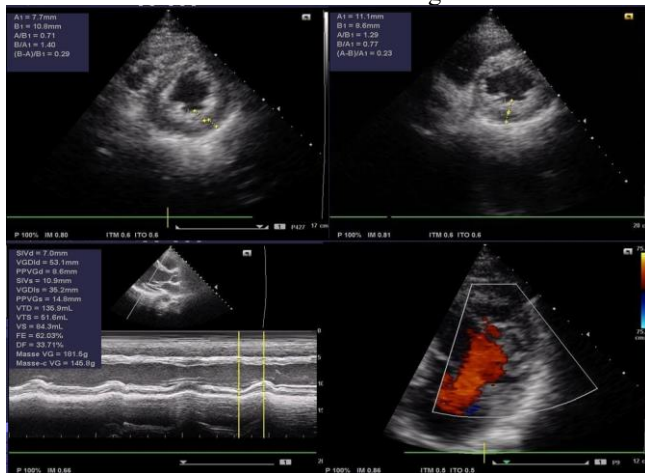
Cardiac ultrasound showing trabeculations in the left ventricle
